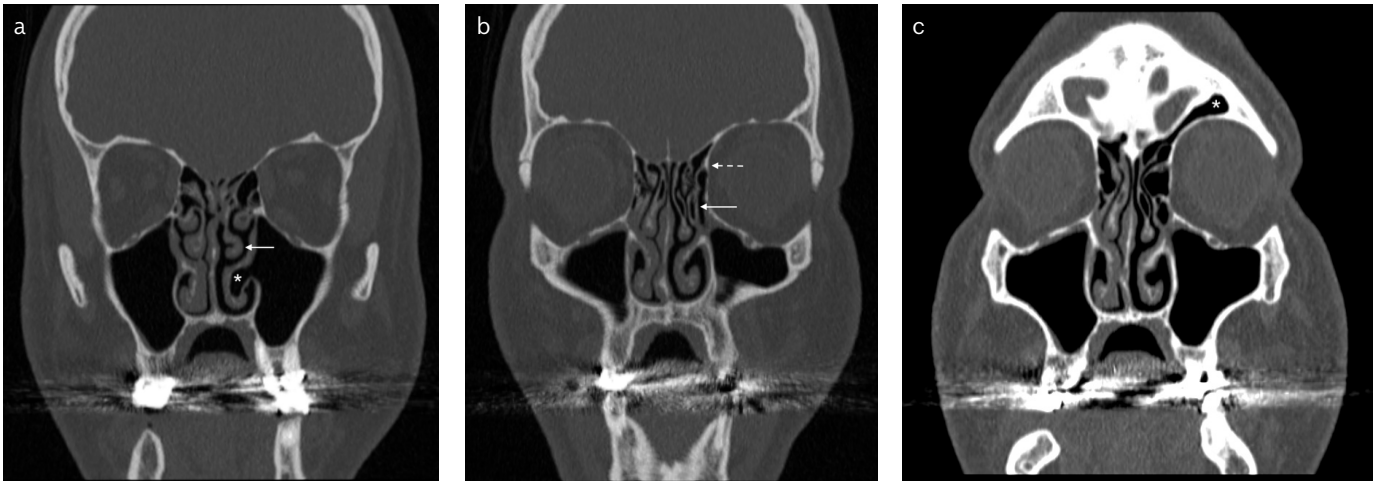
a-c. Coronal computed tomography images of the bone window display the anatomical variations of the left nasal cavity. (a) Left paradoxical middle concha (white arrow) and left inferior concha bullosa connected with left maxillary sinus (white asterisk). (b) Left uncinata bullosa (white arrow) and its attachment to the lamina papyracea (dashed white arrow). (c) Supraorbital ethmoid cell (white asterisk).
